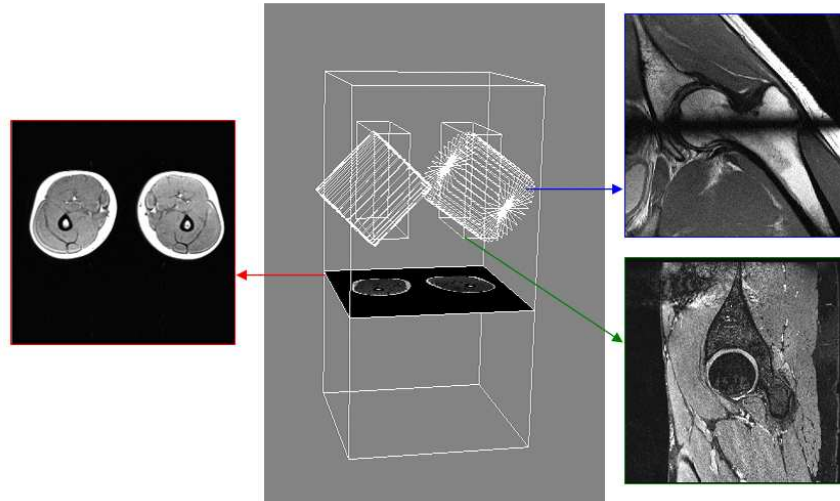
Sequential MRI protocol for the analysis of coxo-femoral conflicts
